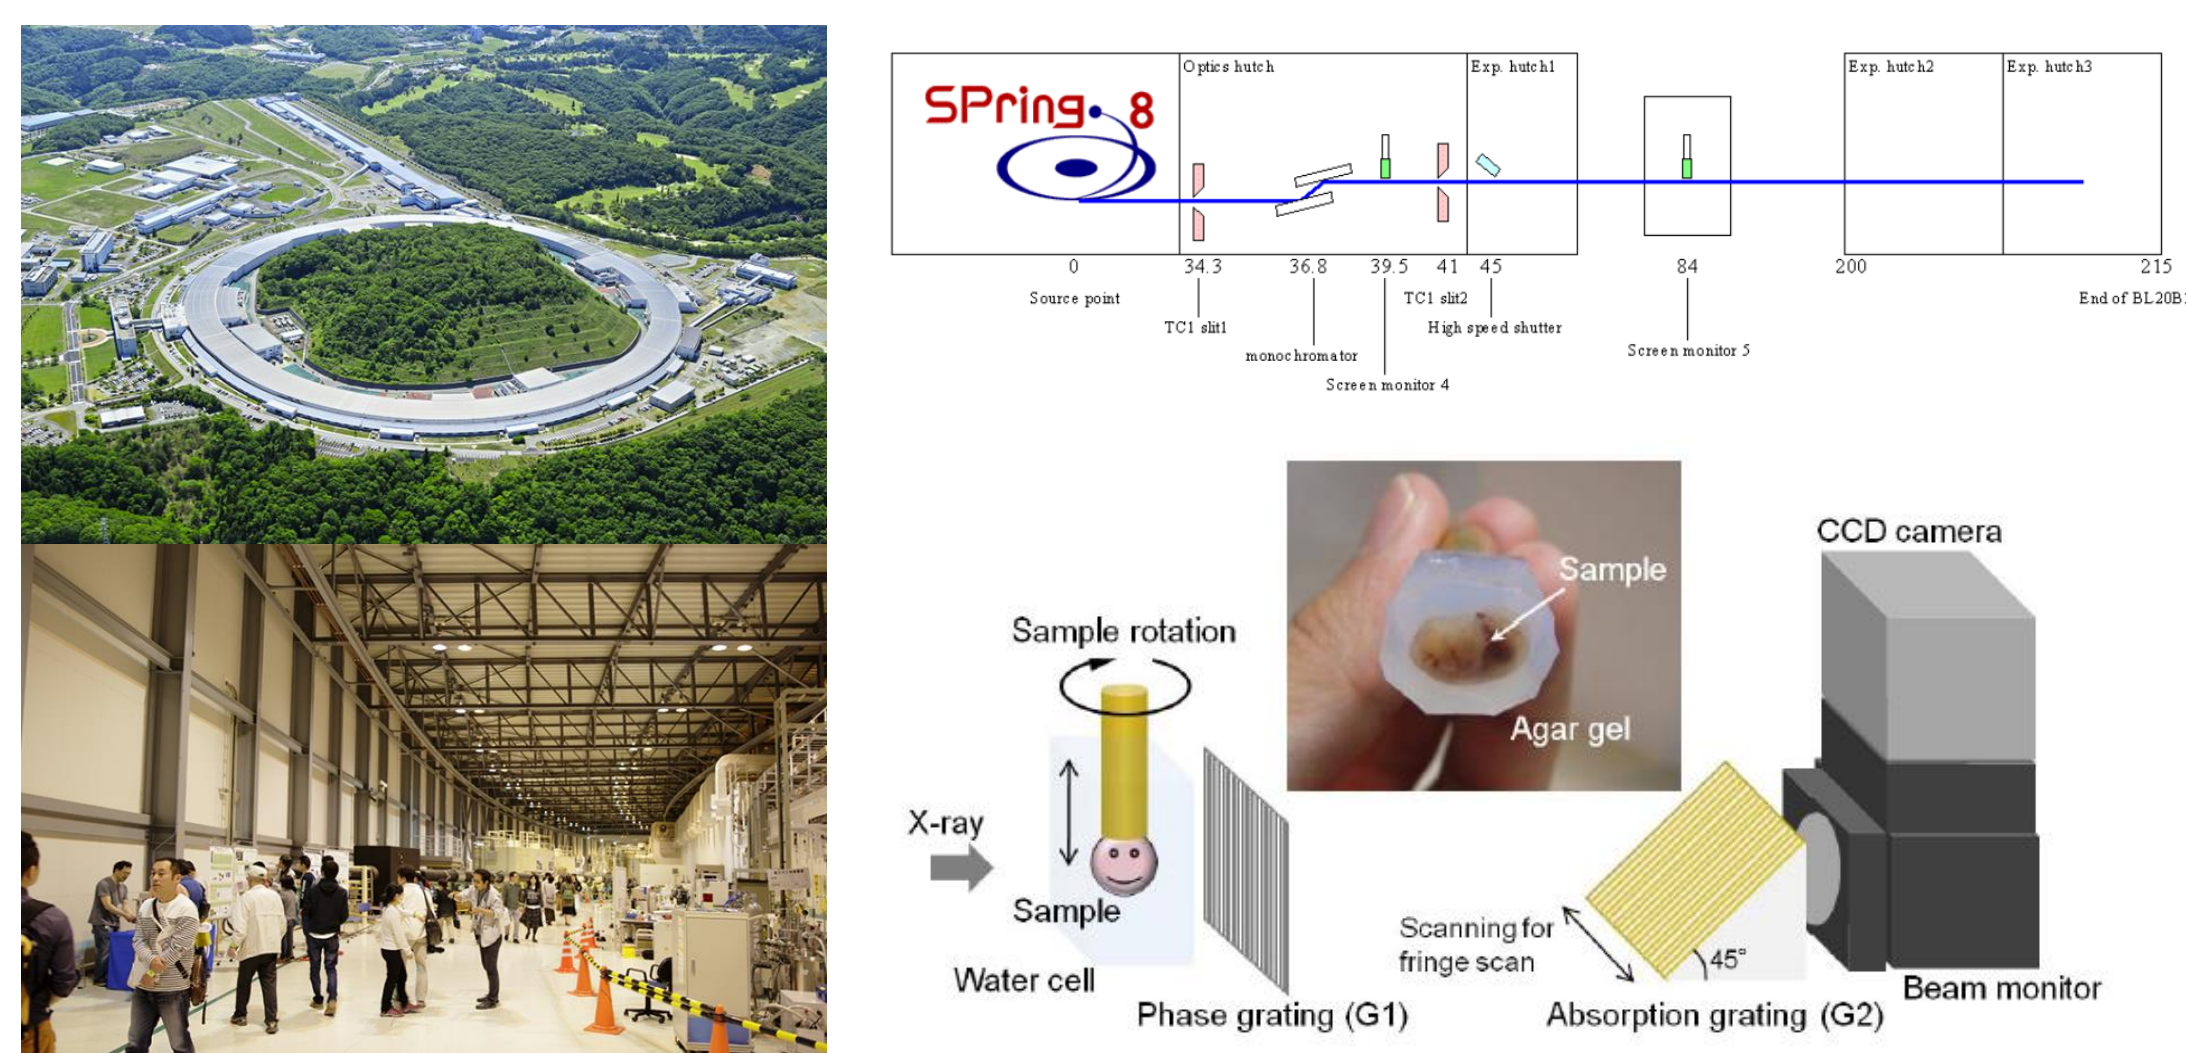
Spring-8: X-ray Phase Contrast Tomography, Harima, Japan.
